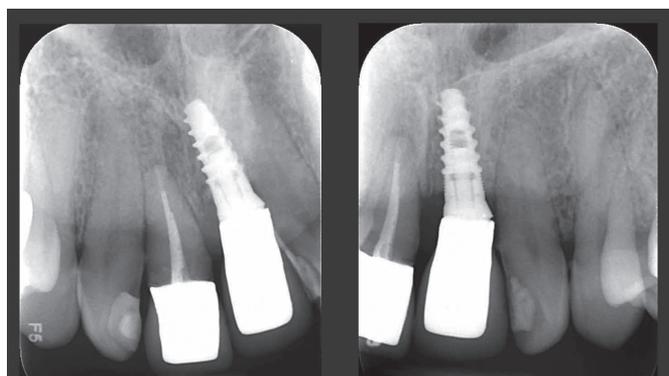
Female patient, 38 years old - implant on upper left central incisor (2.1) radiographic image from two incidents.
